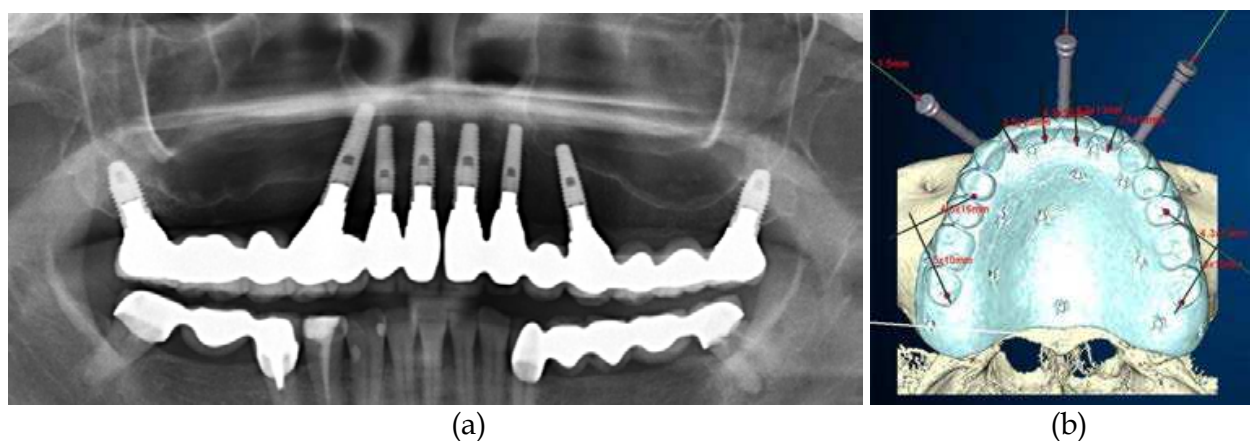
Parasinusal placement of tilted implants in the atrophic maxilla (a) using CT-based implant treatment planning software (b) [pictures by Werner Zechner\*]
